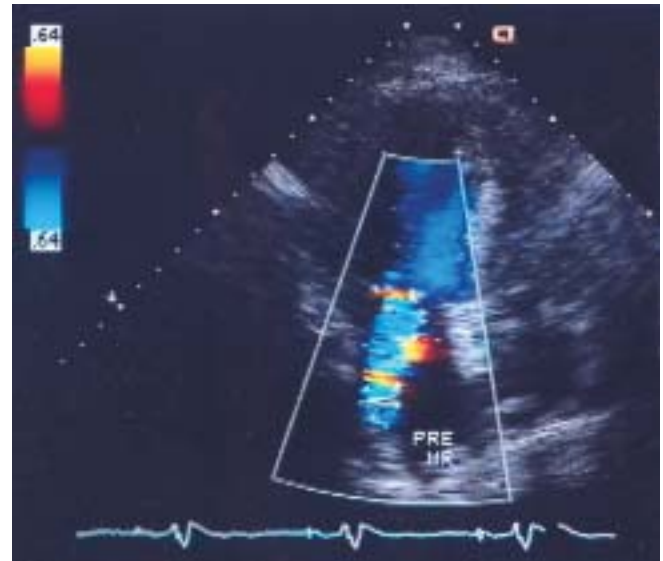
Color flow Doppler image of MR at rest.
